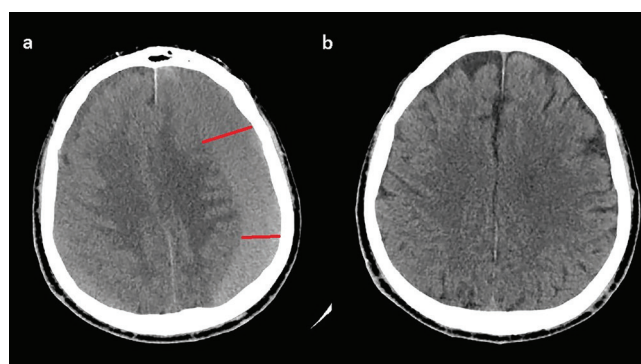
Left frontoparietal wide subacute subdural hematoma (a). Postoperative CT on the 3rd day. Subdural space was completely closed, the parenchyma was completely expanded, and there was no pneumocephalus (b).
